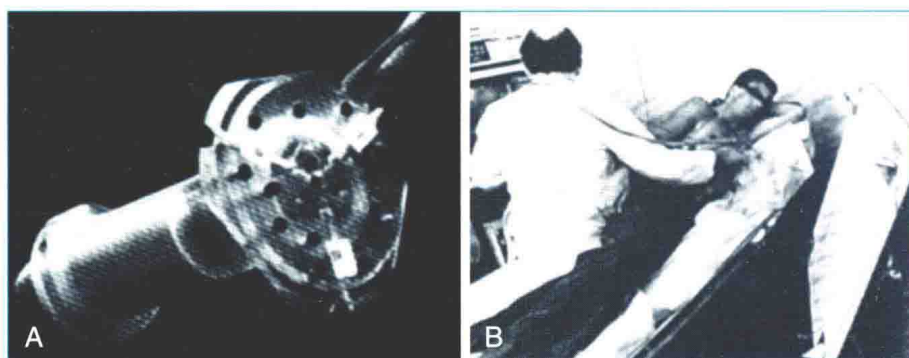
An acoustic "spark gap" apparatus used by Moritz and Shreve² for locating the transducer for three-dimensional echocardiography. A, Actual device housing the transducer, with the audio signal sent from the trifurcating mechanism. B, The device in practice, with the coordinates shown on the board to the right of the user.
